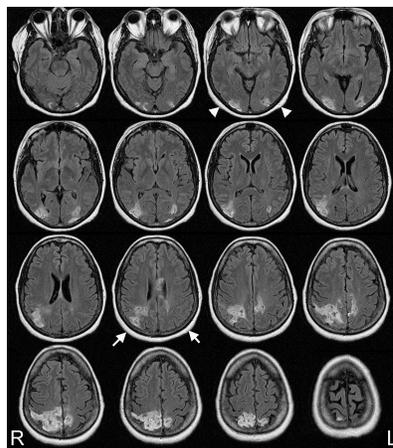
Axial FLAIR sequences of MRI scans for patient SL. R = Right, L = Left side of the brain. Arrowheads indicate the junction of Brodmann areas 19 and 37, while arrows indicate the junction between areas 39 and 40.
